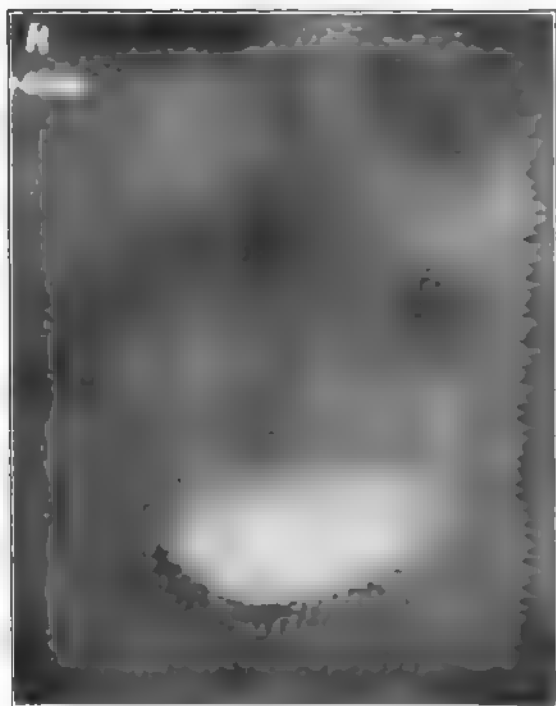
(Case No. A90,713, X-ray No. 24,338.) Residue after six hours
